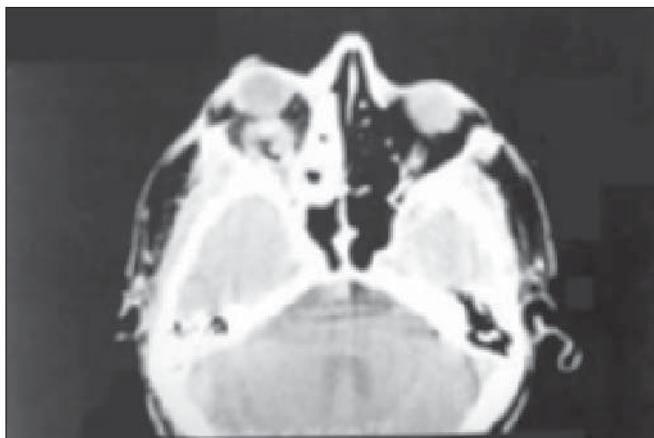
CT Scan of mucormycosis in the orbital apex
